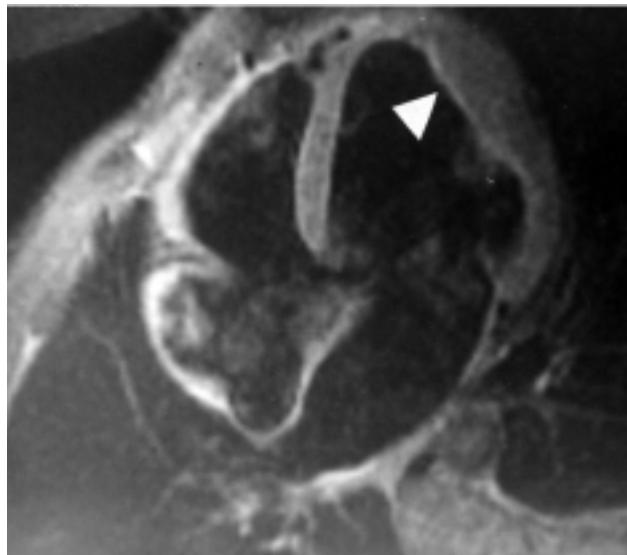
Magnetic resonance image in the coronal orientation demonstrates a hypertrophic region in the LFW in the left ventricle (arrow), with normal myocardial segment shortening.
